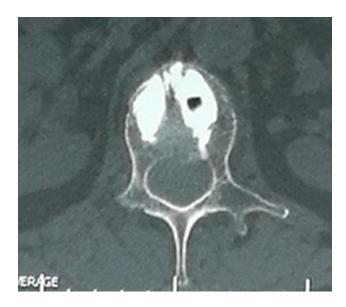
While there was no obvious intraspinal cement leakage on the postoperative lumbar computed tomography, there is visible dispersion of the bone cement on the left side of the vertebral body along the puncture trajectory, whose extension line is medial to the inner wall of the pedicle.
